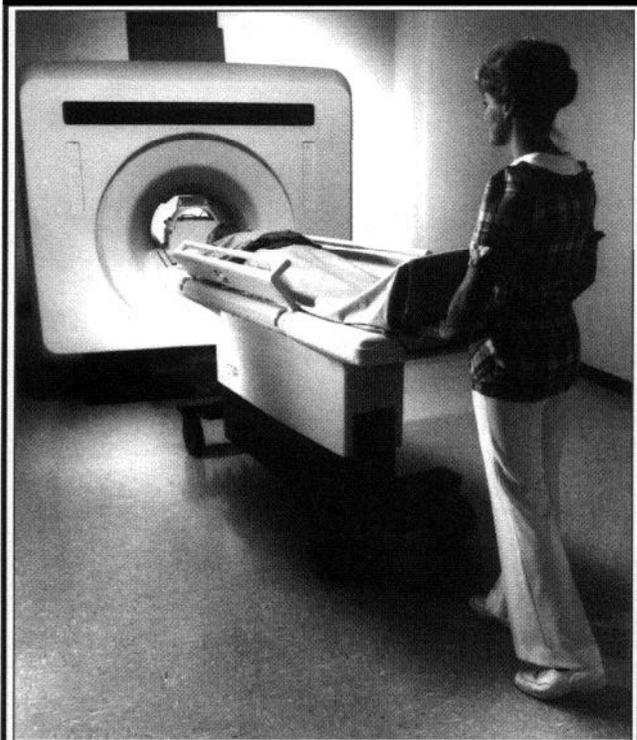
A combination of DC and radio-frequency AC magnetic fields are used in magnetic resonance imaging devices. These devices produce high-resolution pictures of internal body parts Source: General Electric Co.
